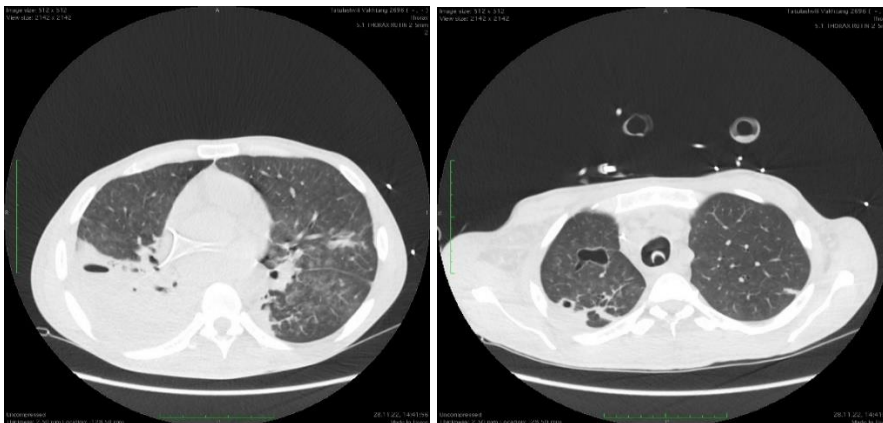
CT scan of the chest.
